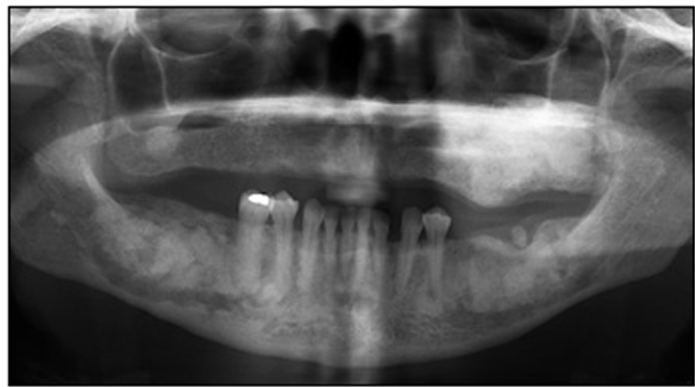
Panoramic radiograph showing multiple radiopaque masses involving the mandible and maxilla.
